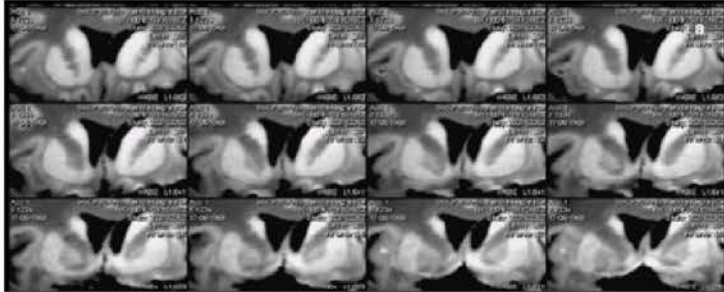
An MRI image of a Human Nucleus Accumbens. Retrieved from a study done by Lia Lucas Neto and others.
